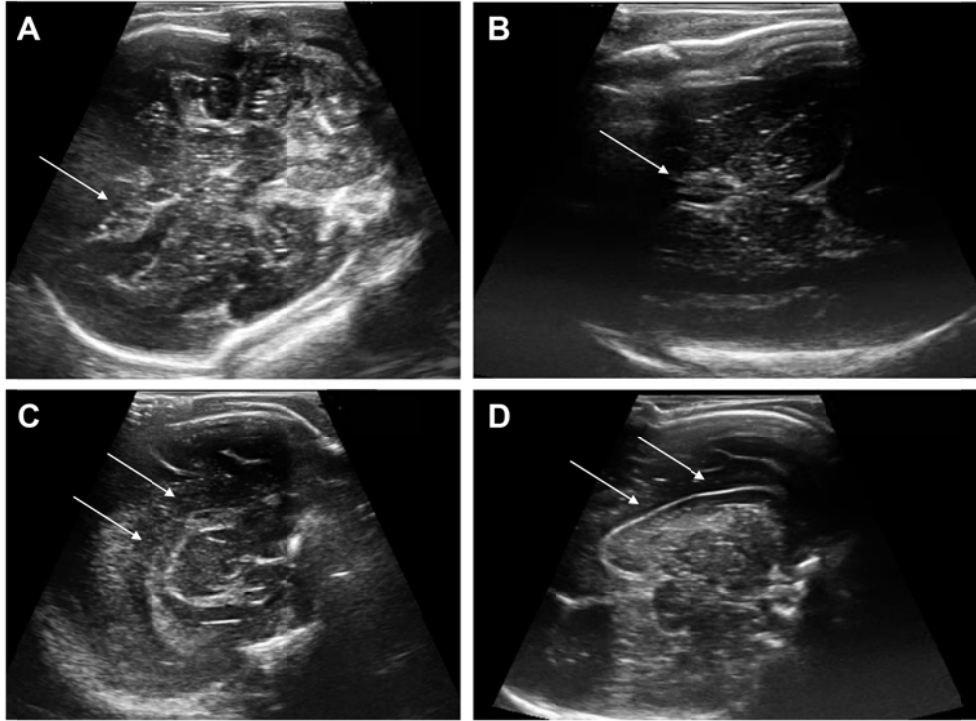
Postmortem ultrasound imaging.
